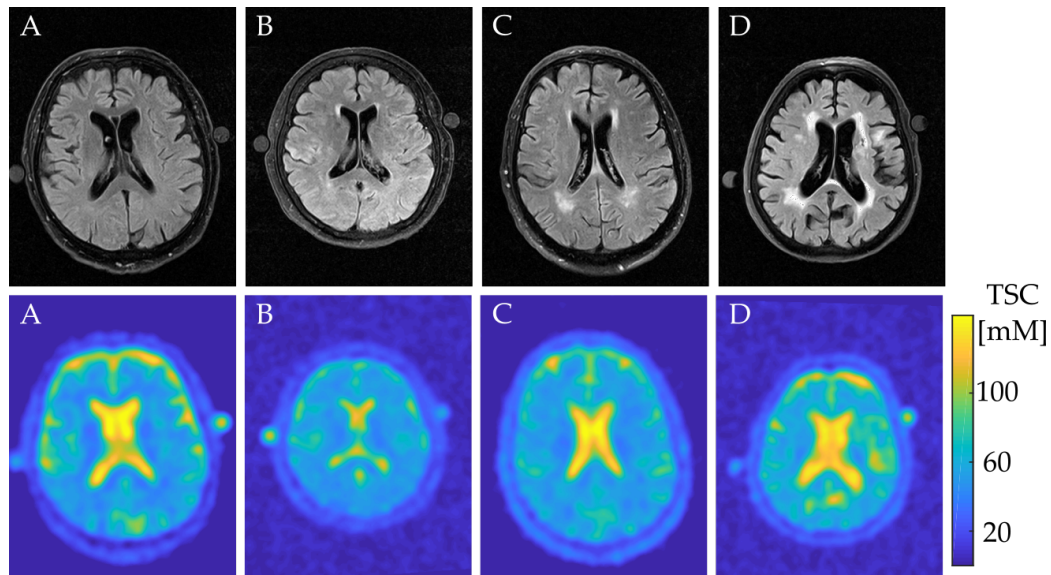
Transverse slice of the  $^1\text{H}$  FLAIR and the co-registered quantified  $^{23}\text{Na}$  MR images from a patient with A: Fazekas grade 0 (male, 80 years old), B: Fazekas grade I (female, 59 years old), C: Fazekas grade II (male, 77 years old), D: Fazekas grade III (female, 83 years old). This figure is adapted from [Adl+21b] with permission.
